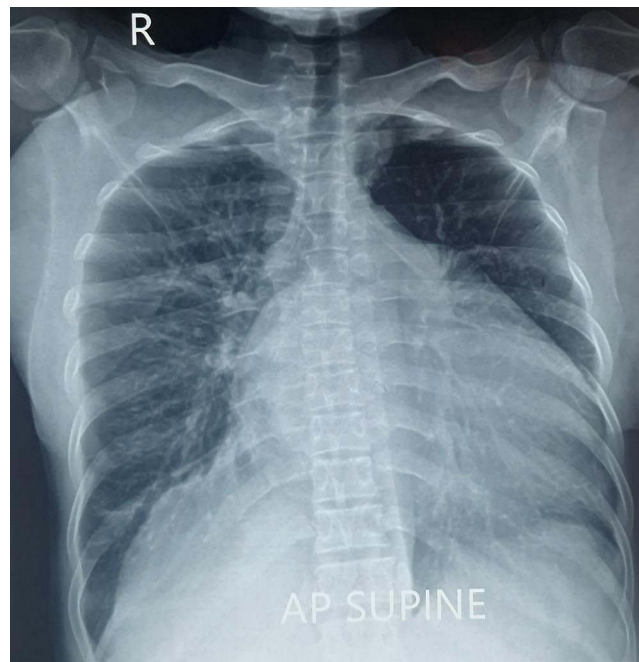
Chest X-ray on the 3rd visit. Chest X-ray (follow-up) showing persistent cardiomegaly (with R = right side and AP = anteroposterior view).
